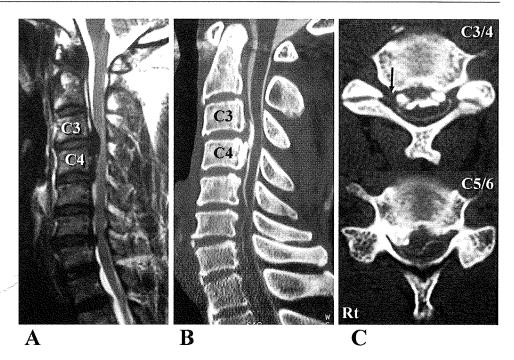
These 3 images of the cervical spine (A-C) were obtained before surgery in a 52year-old man with cervical myelopathy caused by ossification of posterior longitudinal ligament (OPLL). A midsagittal T2weighted magnetic resonance image (A) shows severe compression of the spinal cord anteriorly at multiple levels from C3/4 to C6/7. Midsagittal (B) and axial (C) computed tomographic images show anterior broad compression of the spinal cord by a large OPLL at C3/4 and anterior right-sided compression of the spinal cord by soft disc herniation at C5/6. An arrow (C, upper panel) indicates the site where cerebrospinal fluid leakage and subsequent massive bleeding occurred during surgery.
